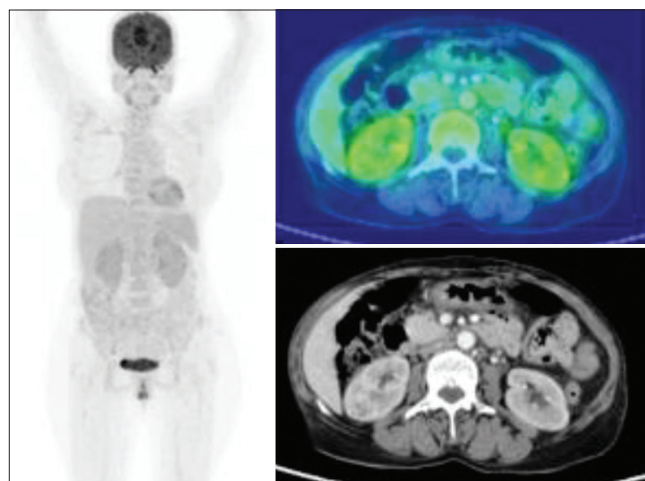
Negative positron emission tomography-computed tomography scan in a patient with granulomatosis with polyangiitis. Final diagnosis was confirmed by antineutrophilic cytoplasmic antibody, and renal biopsy (False negative positron emission tomography-computed tomography scan)
